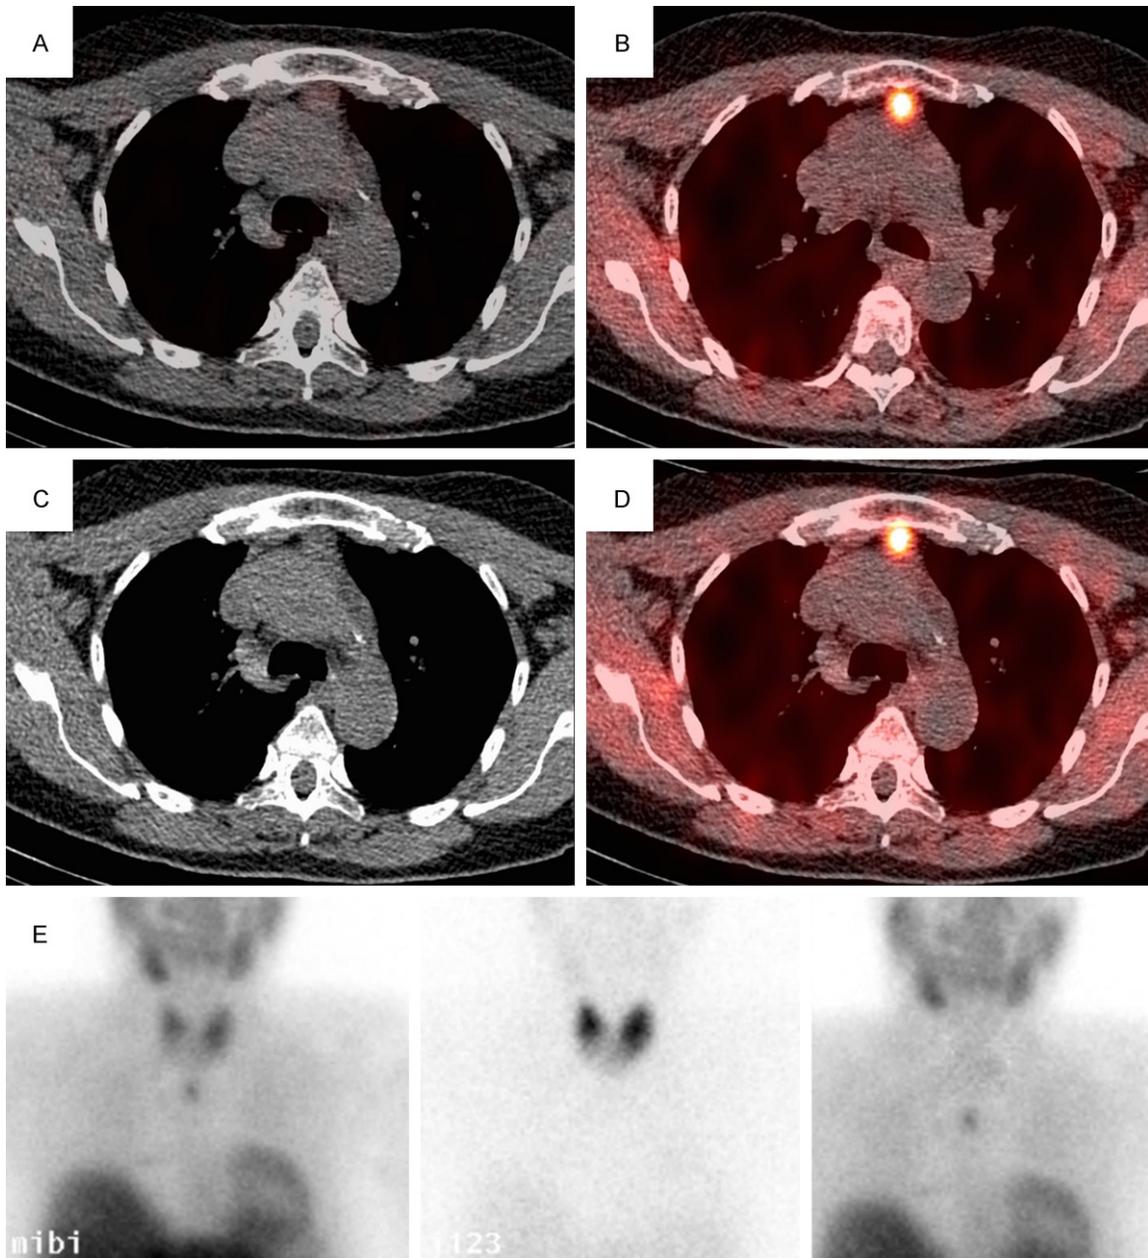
Example of an ectopic parathyroid adenoma, localized at the left retrosternal area. Iodine-123 image showing no increased uptake (A), Tc-99m MIBI image with a focal increased uptake retrosternal (B), native CT showing a nodule retrosternal (C), subtraction of Tc-99m MIBI and iodine-123 showing a high residual uptake in the left retrosternal area (D), planar Tc-99m MIBI, planar Iodine-123 and planar subtraction image (E).
